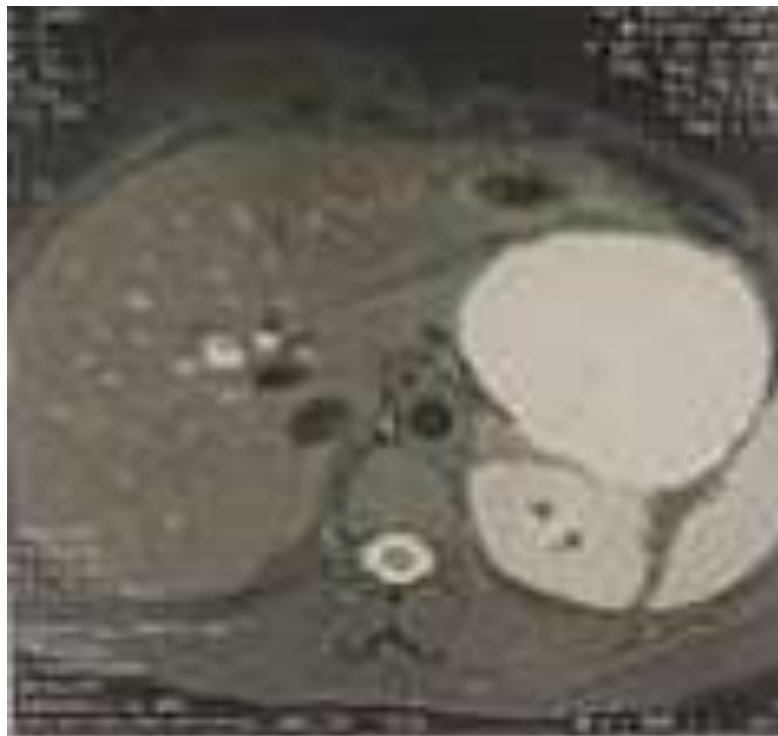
Abdominal MRI showing a well-defined cystic formation in the tail of the pancreas, T2 hypersignal, T1 hyposignal and several partitions delimiting loci (patient 2).
